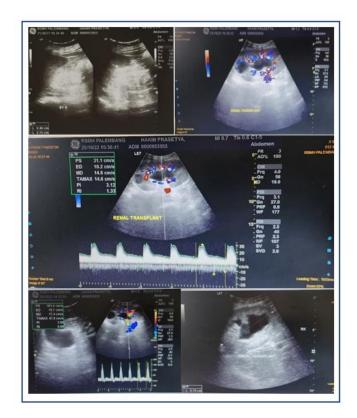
Doppler ultrasound results
